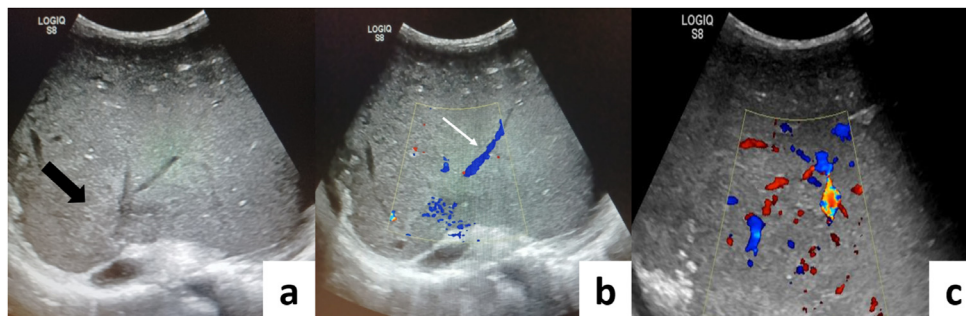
(a) USG shows an enlarged left lobe with heterogeneous parenchymal echotexture, an ill-defined iso to hyperechoic mass (black arrow) involving LHV; (b, c) Colour Doppler shows monophasic flow in LHV, s/o LHV stenosis with multiple tiny intrahepatic veno-venous collaterals.
